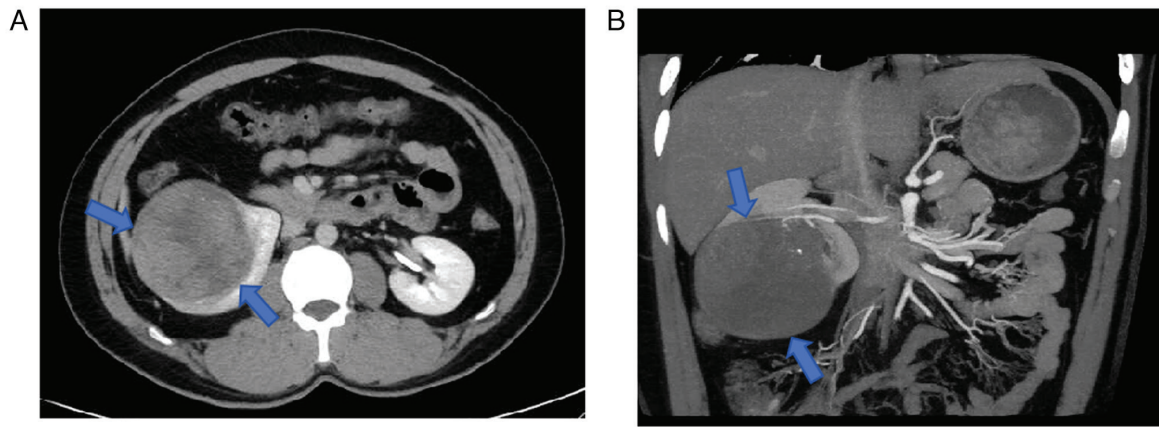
Preoperative CT findings. (A) Abdominal enhanced CT reveals that a lesion (blue arrows) is visible in the mid-lower pole of the right kidney showing progressively mild and uneven enhancement. (B) The right renal CT angiography reveals arterial supply from the right renal artery, with relatively sparse internal vascularity within the tumor (blue arrows).
